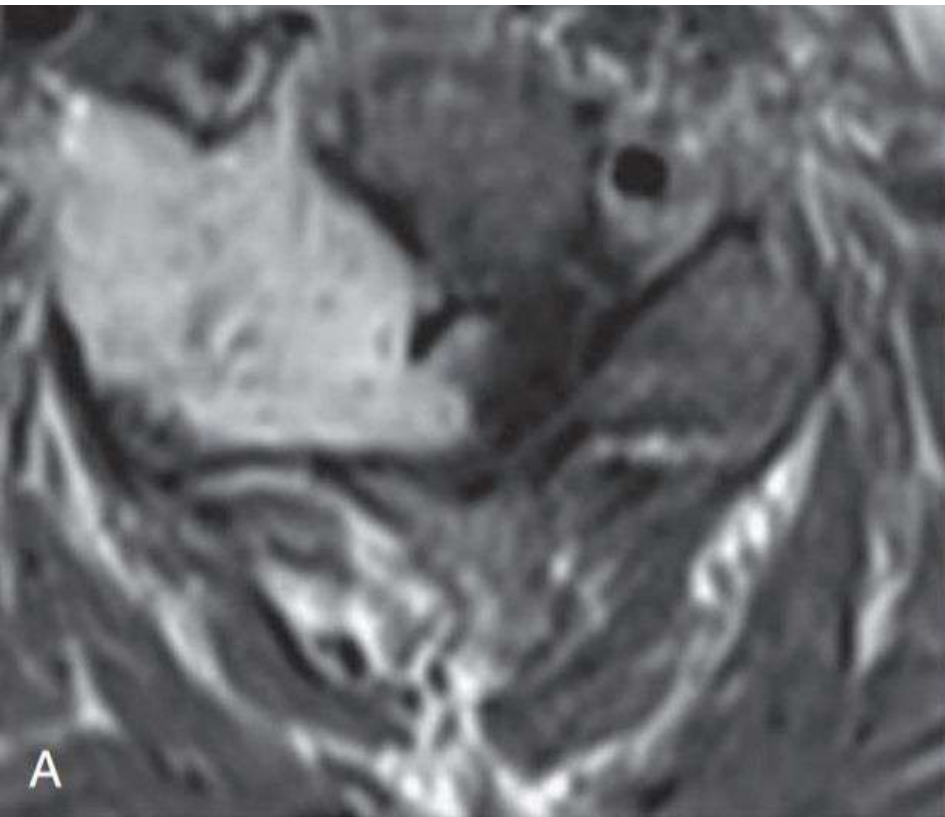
(A) Axial T1-weighted gadolinium-enhanced magnetic resonance image of a malignant neurofibroma expanding the right neural foramen and extending into the extraspinal space. (B) Axial computed tomography of the same mass showing the extensive bony erosion caused by the tumor.
